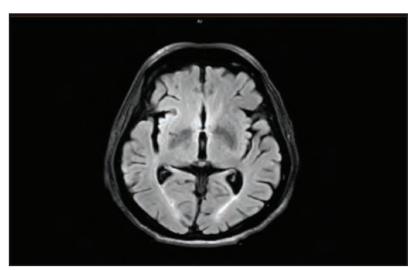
MRI of the brain showing small vessel disease and age-related cerebral atrophy
